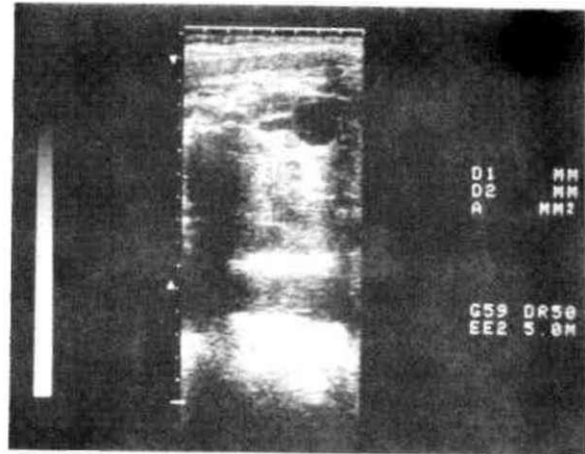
Ultrasonic appearance of left hydronephrotic kidney.
